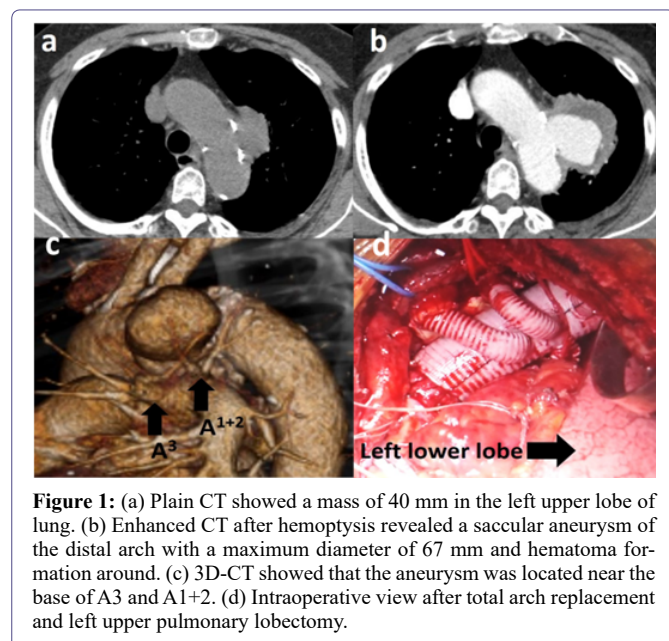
(a) Plain CT showed a mass of 40 mm in the left upper lobe of lung. (b) Enhanced CT after hemoptysis revealed a saccular aneurysm of the distal arch with a maximum diameter of 67 mm and hematoma formation around. (c) 3D-CT showed that the aneurysm was located near the base of A3 and A1+2. (d) Intraoperative view after total arch replacement and left upper pulmonary lobectomy.
